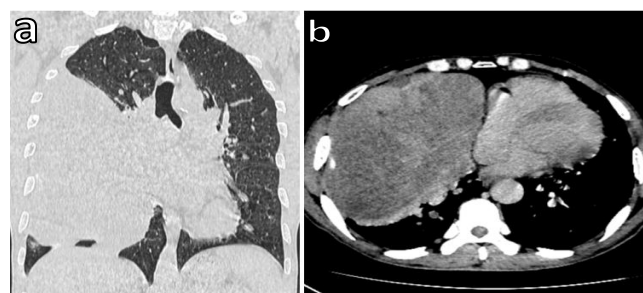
Thoracic CT in parenchymal (A) and mediastinal (B) windows showing a diffuse right pleural tumor mass compressing the right lung and mediastinal structures
